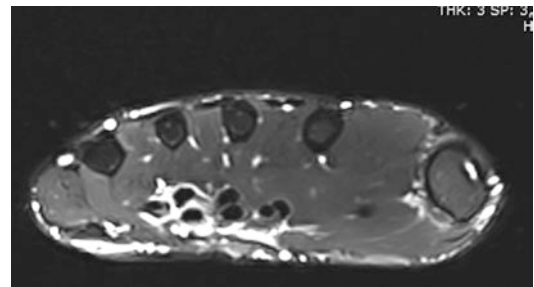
Tenosynovitis of the palm in an MRI imaging
